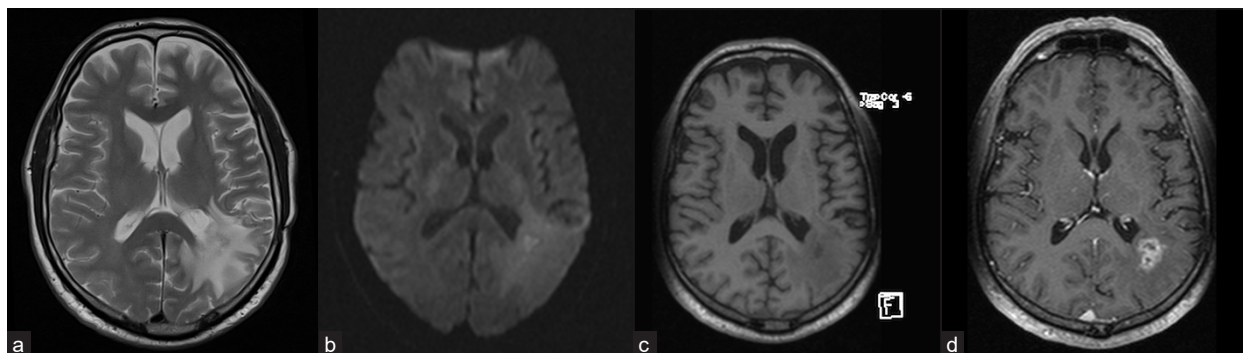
Contrast-enhanced MRI of the brain before sPDT: (a) T2; (b) DWI (b 1,000); (c) T1, before contrast; and (d) post-contrast T1.
